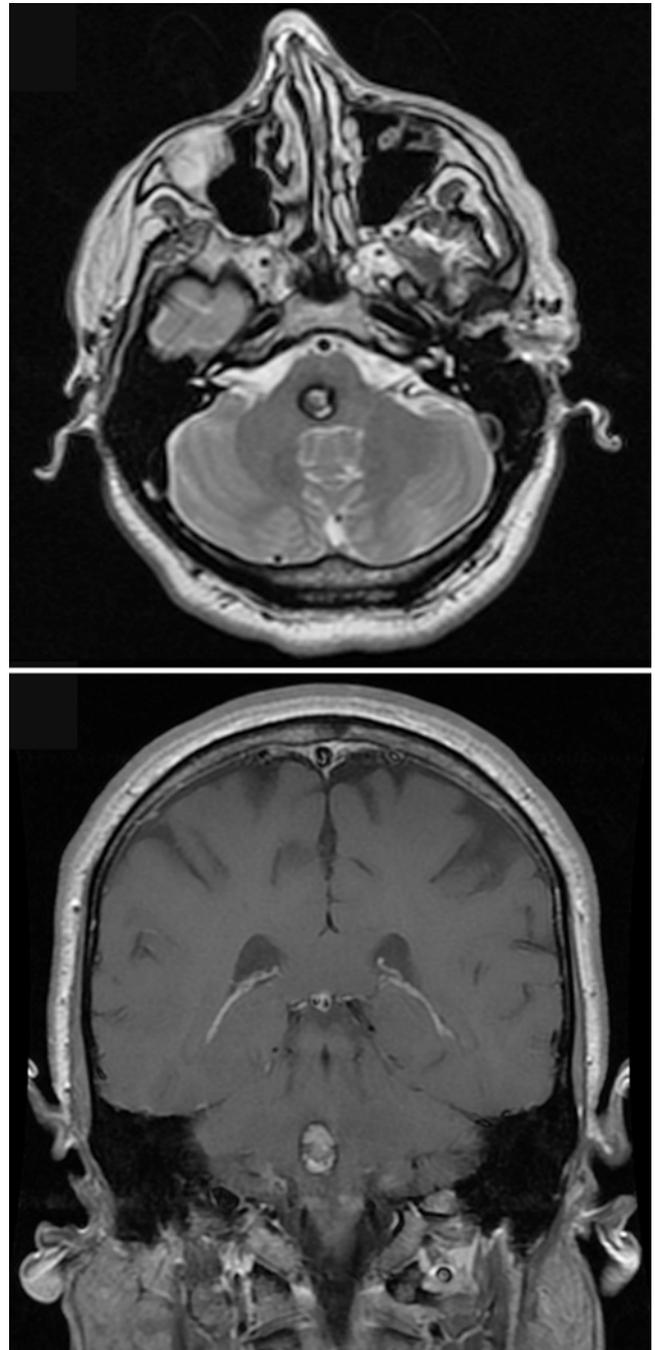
Axial (upper) and coronal (lower) T1-weighted MR images of a cavernous malformation in the brainstem. The lesion demonstrates the heterogeneous signal characteristics of hemorrhage in various stages of resolution.
